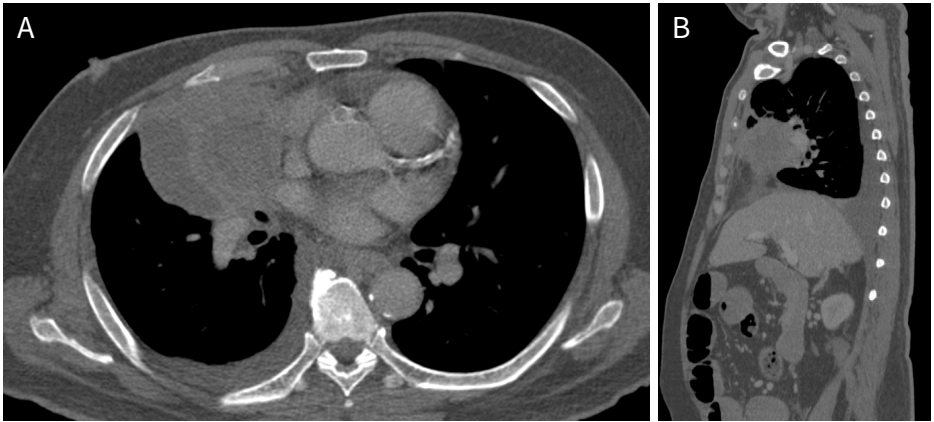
(A) Axial section of contrast-enhanced computed tomography (CECT) of the thorax. (B) Sagittal section of CECT of the thorax shows enhancing mass (white arrow) with hyperdense centre arising from the anterior segment of right upper lobe.
